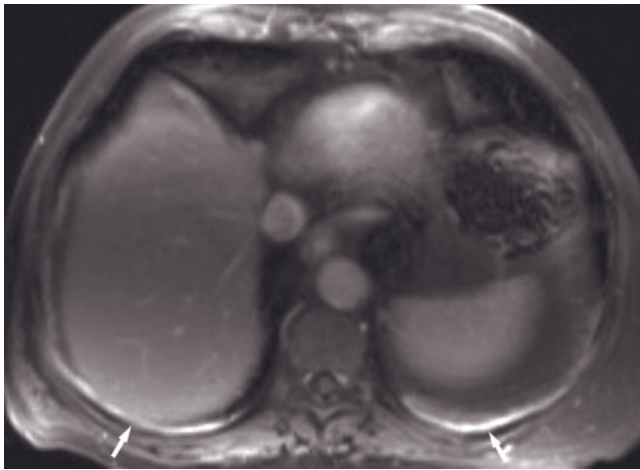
Peritoneal metastases from non-ovary gynecological malignancies. Coronal T2-weighted SS-ETSE (*a*), transverse (*b*) and sagittal (*c*) 512-resolution T2-weighted echo-train spin-echo, and interstitial-phase gadolinium-enhanced SGE (*d*) images in a patient with fallopian tube carcinoma. Extensive peritoneum-based metastases are present that appear intermediate in signal intensity on T2-weighted images (*a-c*). The coronal image demonstrates an irregular layer of metastatic deposit measuring up to 2cm in thickness along the diaphragmatic surface and the liver capsule (small arrows, *a*). Bulky peritoneal metastases are present in the left lower abdomen (large arrow, *a*) and in the pelvis. The transverse high-resolution T2-weighted image demonstrates extensive bulky peritoneal metastases (arrows, *b*). Peritoneal seeding along the peritoneal reflection over the bladder (*b, c*) is well shown on the sagittal plane image (small arrows, *c*). Heterogeneous and moderate enhancement of the metastases is shown on the gadolinium-enhanced fat-suppressed SGE image obtained at the midabdomen level (*d*). Interstitial-phase gadolinium-enhanced fat-suppressed SGE image (*e*) in a second patient who has endometrial stromal sarcoma demonstrates extensive peritoneal involvement including multiple peritoneal nodules (arrows, *e*).
